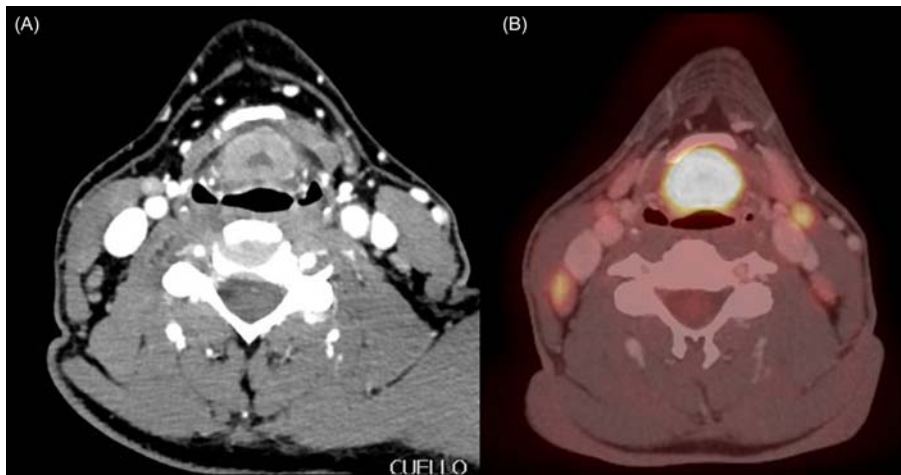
(A) Axial contrast enhanced CT depicting a supraglottic tumor invading the preepiglottic space. (B) PET-CT showing a hypermetabolic focus of active tumor occupying the preepiglottic space that corresponds to the CT abnormality.
